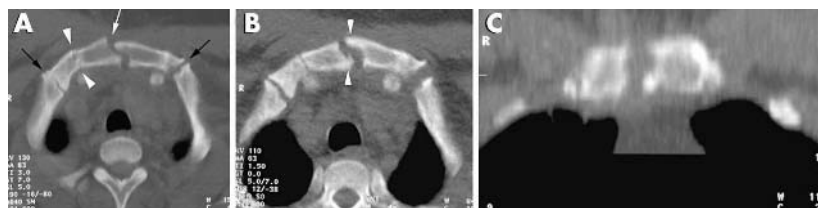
(A) Thoracic CT axial images show a vertical midsternal, slightly displaced fracture (white arrow) on the manubrium sterni extending to the body of the sternum. Manubriosternal synchondrosis is seen on the right lateral side of the manubrium (arrowheads). Costosternal joints are also seen (black arrows). There is slight joint widening on the left costosternal joint compared with the right side. (B) Control CT scan shows sclerotic medullary bone changes caused by healing of the fracture line (arrowheads). Widening of the left costosternal joint had increased compared with the previous examination. (C) Coronal reformatted image shows the vertical midline fracture line more clearly.
